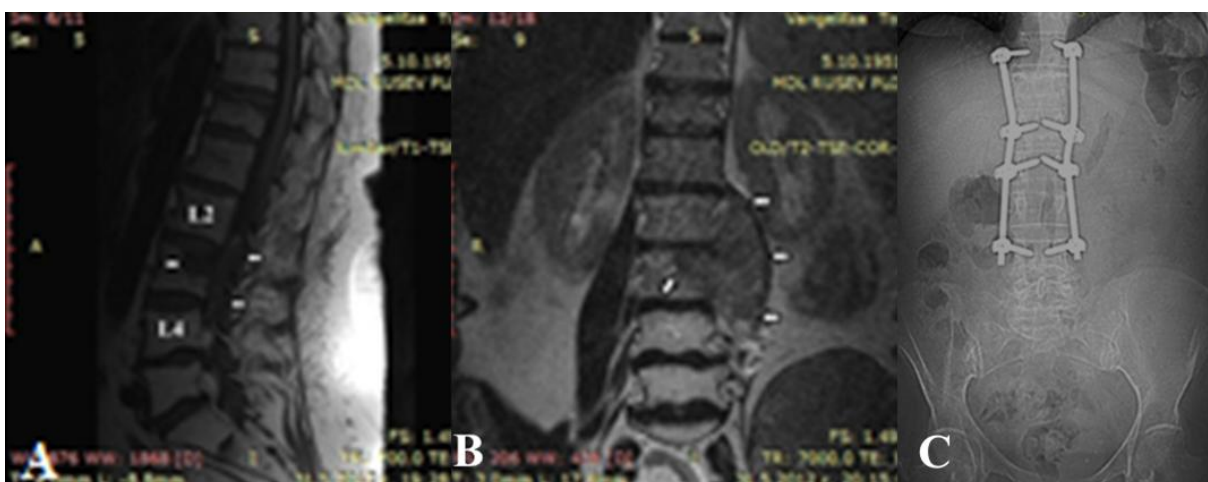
MRI of the paravertebral myeloma affecting L₂₋₃ level which compresses the nerve roots of cauda equina: A/ sagittal projection;
